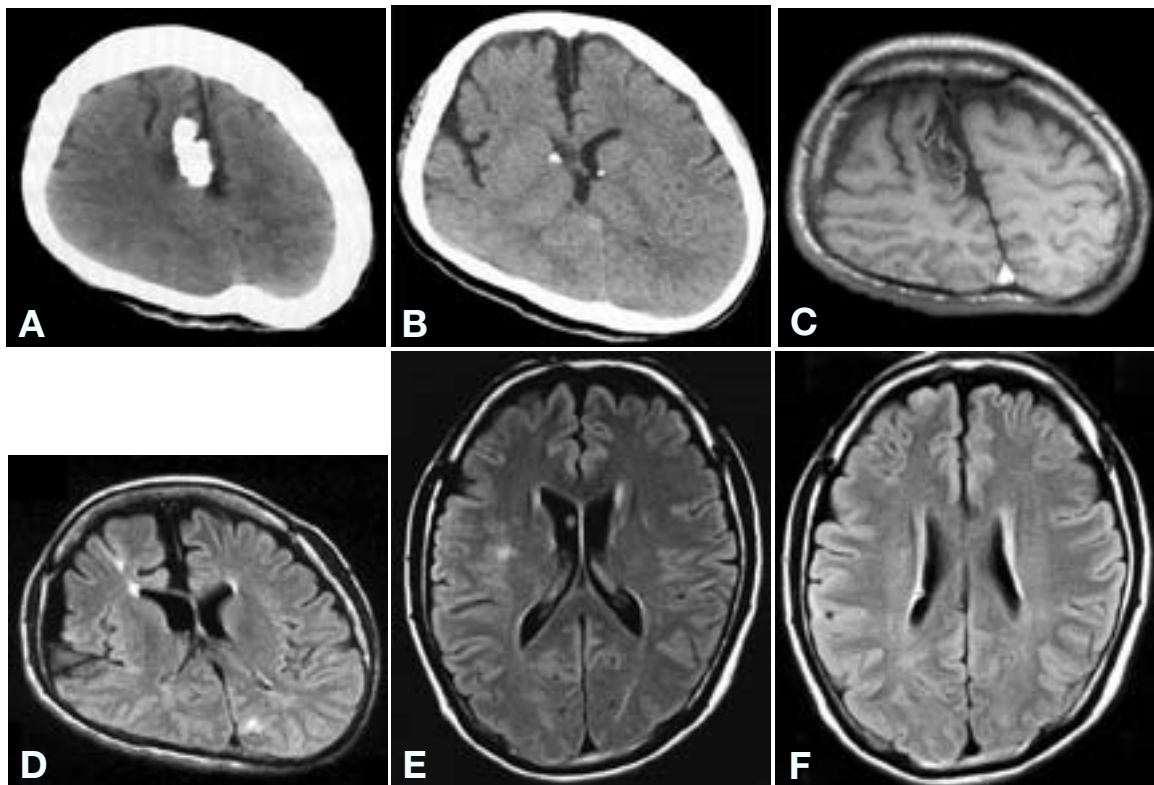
Neuroimaging of patients with *TSC1* p.R509X mutation. A to D: Patient 1. E and F: Patient 2. A and B: computed tomography (CT). C to F: magnetic resonance (MR) imaging [C: T1 weighted image, D to F: Fluid-attenuation recovery images].
